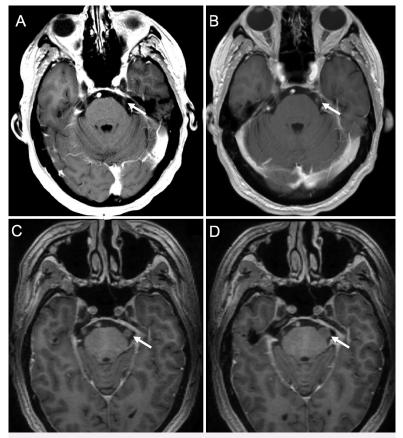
Case 2. Axial T1-weighted postcontrast images demonstrating subtle asymmetric enhancement of the left trigeminal nerve (A), which becomes more prominent on 3-month follow-up imaging (B) and continues to progress to a discrete, minimally to nonenhancing nodule on the 6-month (C) and 9-month (D) follow-up, as indicated by the arrows.
